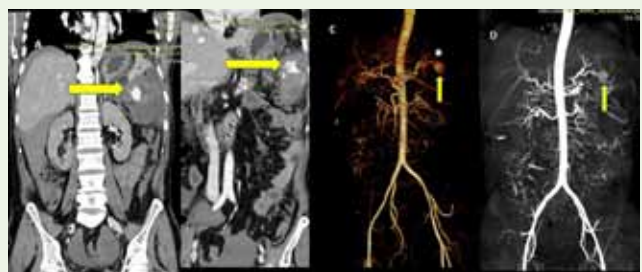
The coronal reconstruction and volume rendering CT angiogram clearly depicts the aneurysm from splenic artery having a peripheral thrombus (arrow in A) with active contrast extravasation (arrow in B). In image C and D, the aneurysm is well shown arising from splenic artery indicated by arrow.
